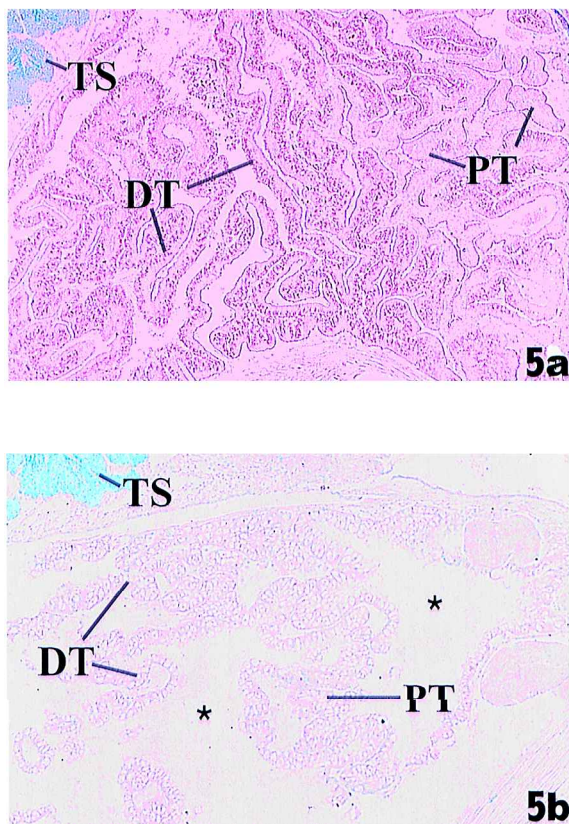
FDGE sections of *Potamocorbula amurensis* kidney reacted for GGT. 5a: Strong GGT positive reactions in distal tubular epithelia cells (DT) and normal positive reactions in proximal tubular epithelia cells (PT) were seen in clam collected from station 12.5. TS = testis. GGT.  $\times 150$ . 5b: No GGT reactions were seen in kidney of clam collected from station 4.1. Severe tubular oedema was seen in the whole kidney (\*). TS = testis. GGT.  $\times 150$ .
